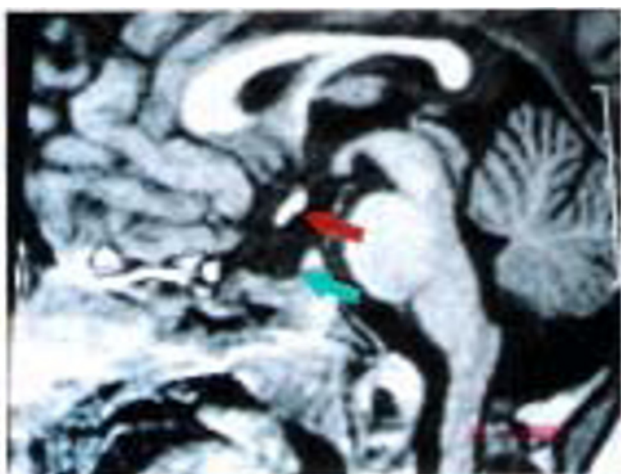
MRI brain with contrast reveals empty sella, anterior pituitary hypoplasia, ectopic posterior pituitary bright spot and non-visualization of stalk.
